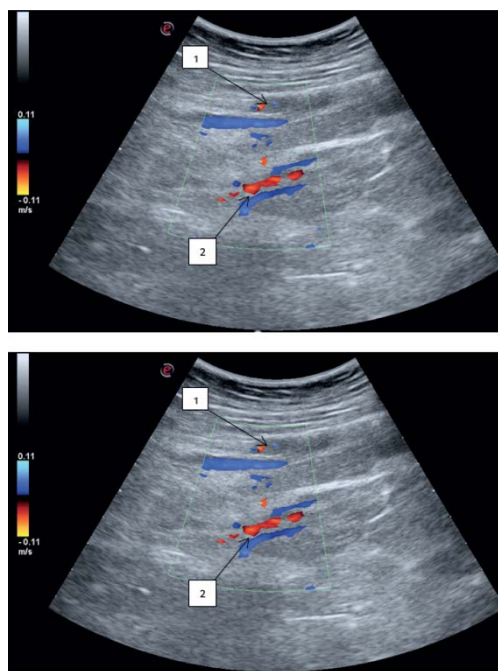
Angioscanogram of the femoral and deep femoral vessels (color Doppler mapping mode). 1, superficial femoral vessels; 2, deep femoral vessels at the level of branches of the second level
